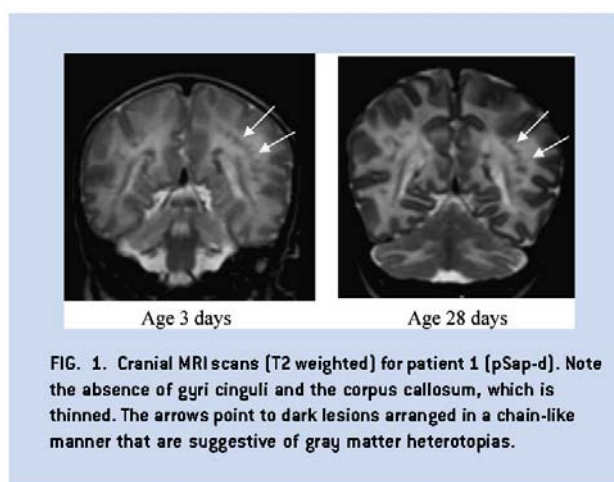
Cranial MRI scans (T2 weighted) for patient 1 (pSap-d). Note the absence of gyri cinguli and the corpus callosum, which is thinned. The arrows point to dark lesions arranged in a chain-like manner that are suggestive of gray matter heterotopias.
